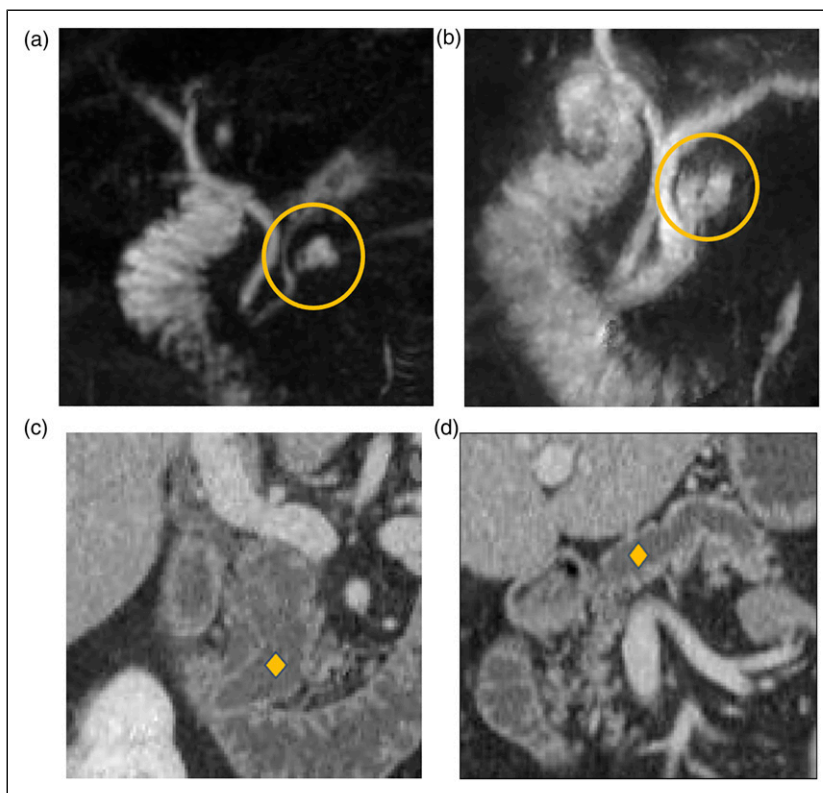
Sixty-three-year-old female with history of idiopathic pancreatitis. Incidentally detected 8 mm PCL at the head (yellow circle) without worrisome features or high-risk stigmata on MRI 2013, considered a BD-IPMN vs pancreatitis-related pseudocyst (A, MRCP radial). Stable on MRI 2016 (B, MRCP radial). Lesion enlarged up to 2.0 cm by 2020 with worsened MPD dilatation up to 13 mm at the uncinata process (yellow diamonds), most concerning for main duct IPMN (C-D, Coronal PV phase CT at uncinata process and body). Surgical pathology confirmed IPMN with high grade dysplasia. PCL: Pancreatic cystic lesions; CT: Computerized tomography; IPMN: intraductal papillary mucinous neoplasms; MPD: main pancreatic duct.
